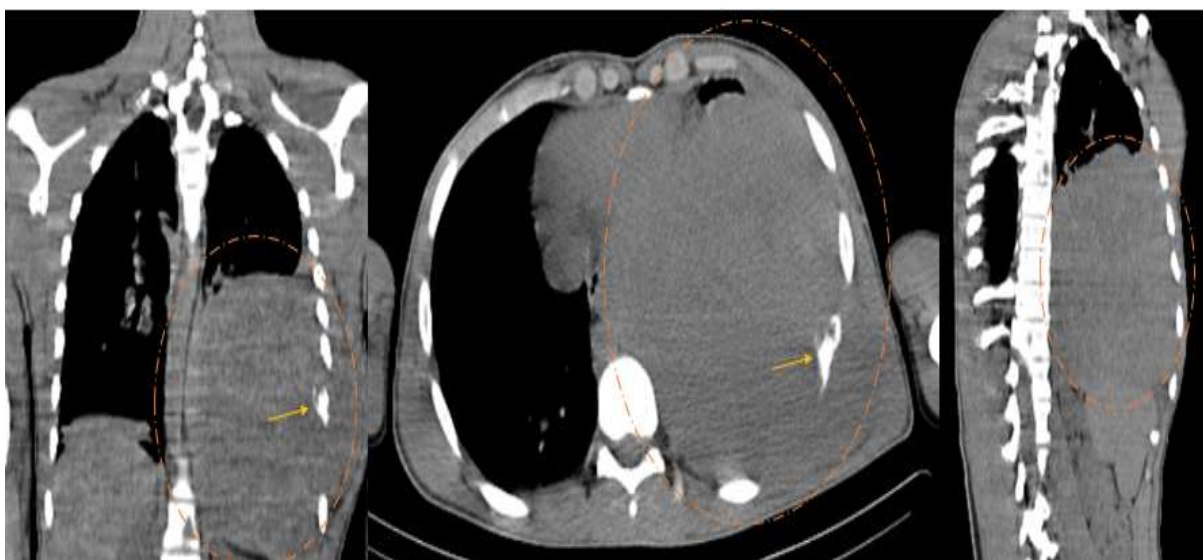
Baseline non-contrast CT of the chest (native scan) in the coronal, axial, and sagittal planes, showing a soft tissue mass originating from the left chest wall. The mass invades the adjacent 8th rib, which demonstrates osteolytic destruction.
